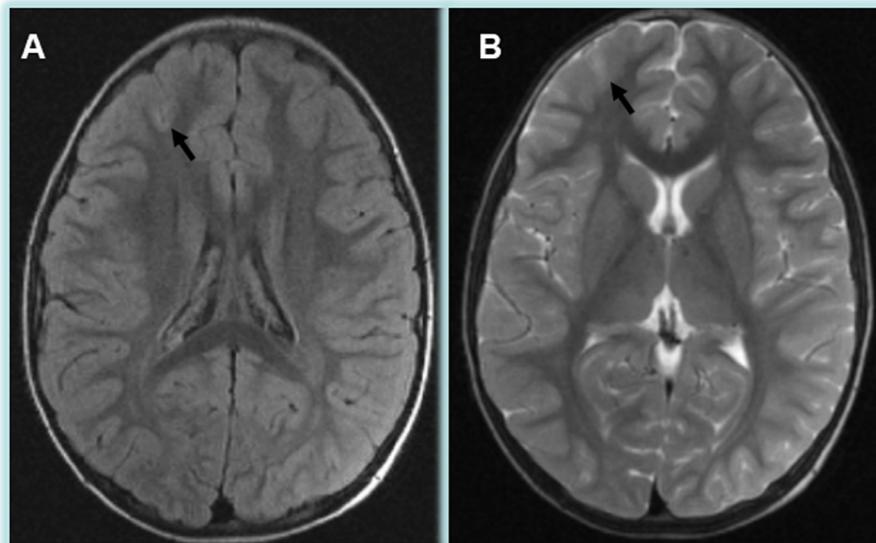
Axial magnetic resonance T2-weighted images (A) and (B) of patient 3 showing subtle white-matter abnormalities in the right middle frontal gyrus/frontal cortex (indicated by arrows).
